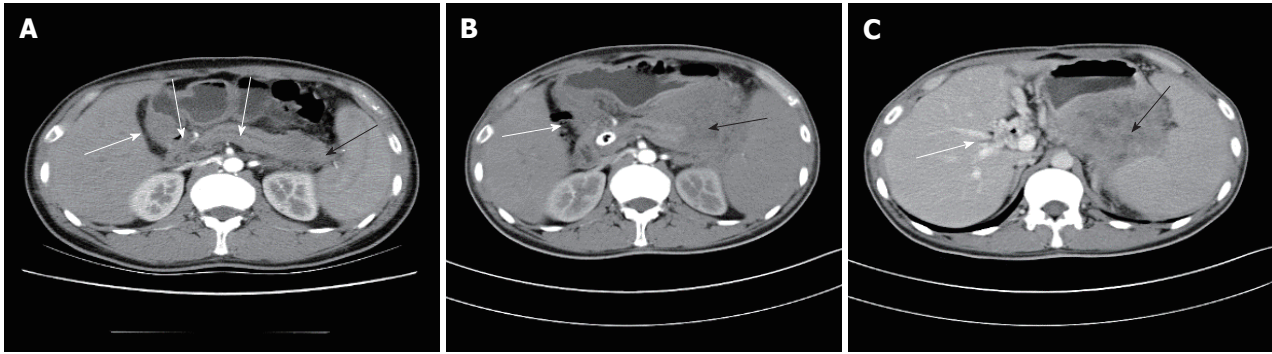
Abdominal computed tomography scan. A. Axial projection shows the pancreatic duct, intrahepatic, and extrahepatic bile duct dilation (white arrow heads) and low-density pancreatic mass (black arrow head); B. Axial arterial phase projection showing intrahepatic bile duct dilatation and pneumobilia (white arrow head) and pancreatic mass enlargement and enhancement (black arrow head); C. Axial portal phase projection showing portal cavernous transformation (white arrow head) and partial enhancement of the pancreatic mass and areas of low density in the center.
